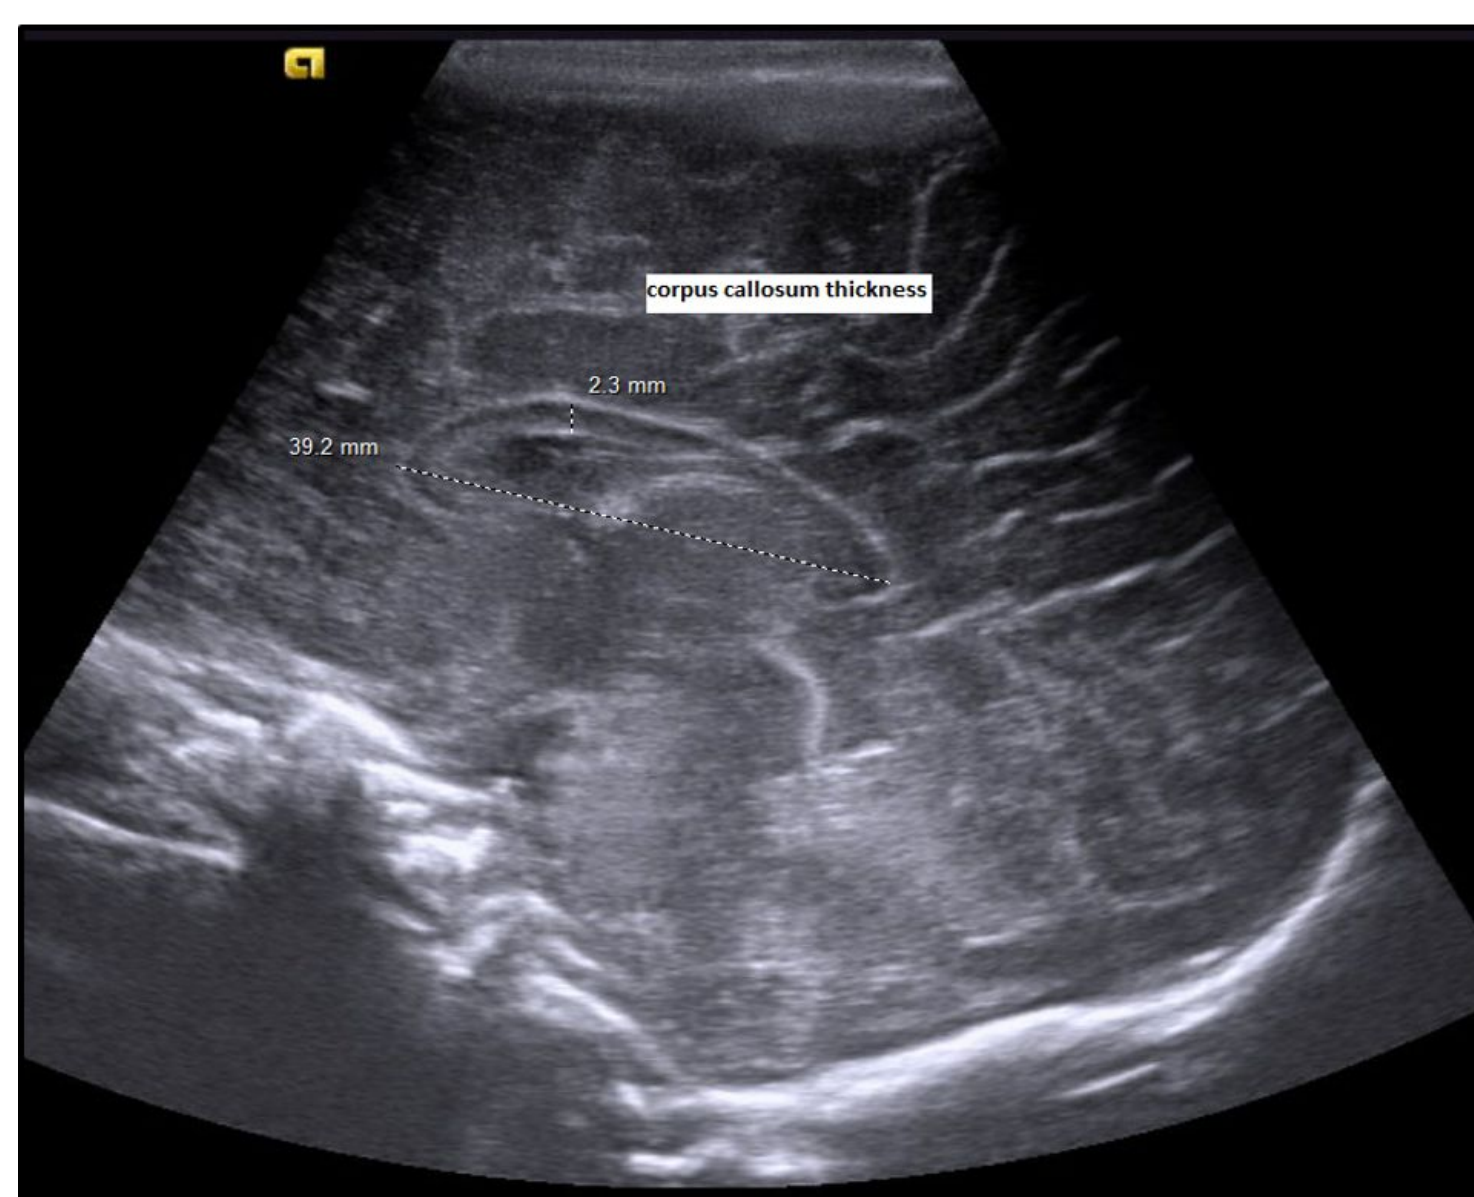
Cranial Ultrasound - Sagittal Section showing corpus callosum.
